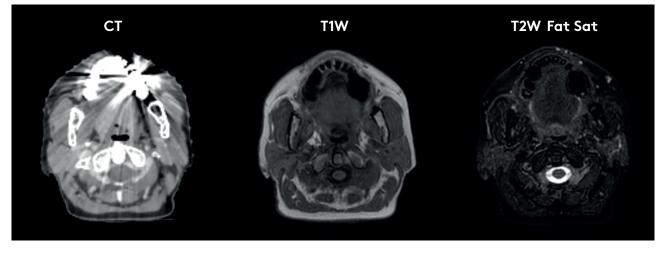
Example of the influence of teeth implant on image quality. On the CT the target area is obscured by metal streak artefacts, where on the MR image a localized signal void is observed.
